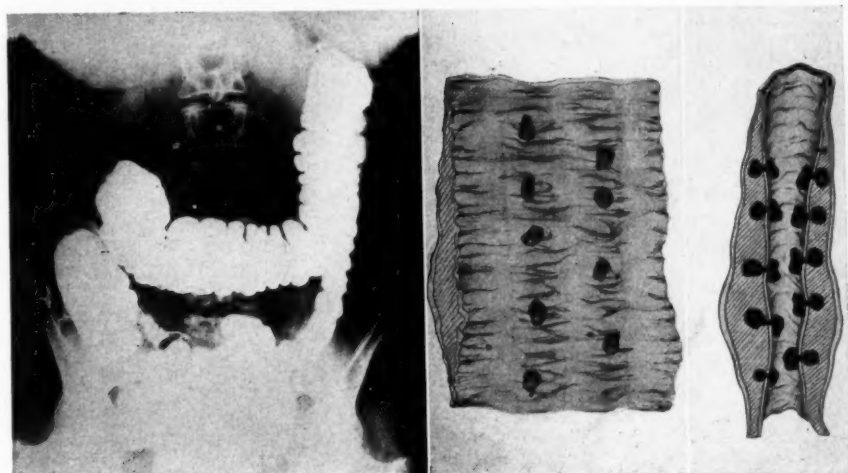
Case 9. A, Diverticulitis of sigmoid not visible by x-ray. B, Sketch of condition found in resected sigmoid.
